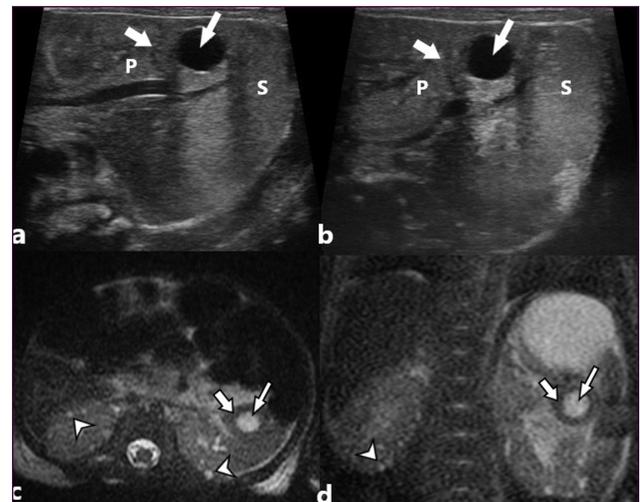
US images of the abdomen (a,b) in one patient show a homogeneously anechoic cyst at the pancreatic tail (long arrows), surrounded by a rim of parenchyma that is isoechoic to the pancreas and demarcated from the pancreas parenchyma with a linear hypoechogenic line (short arrows). Axial and coronal T2-weighted images of the abdomen (c,d) of the same patient show the hyperintense cyst (long arrows) surrounded by a parenchymal rim that is hypointense relative to the pancreatic parenchyma (short arrows). Note the subcapsular cysts of the kidneys (arrowheads).
